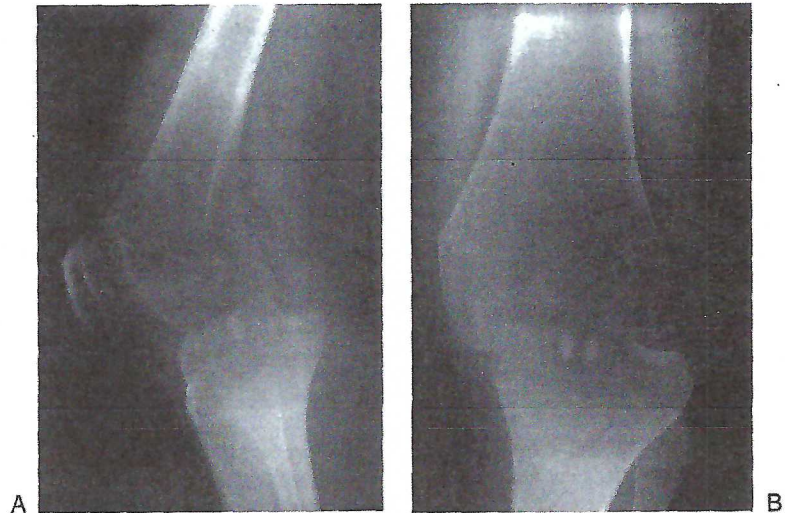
Plain (A) anteroposterior and (B) lateral radiographs demonstrate chronic posterior tibial subluxation. (A From Ref. 17 by permission of *Sports Medicine and Arthroscopy Review*.)
